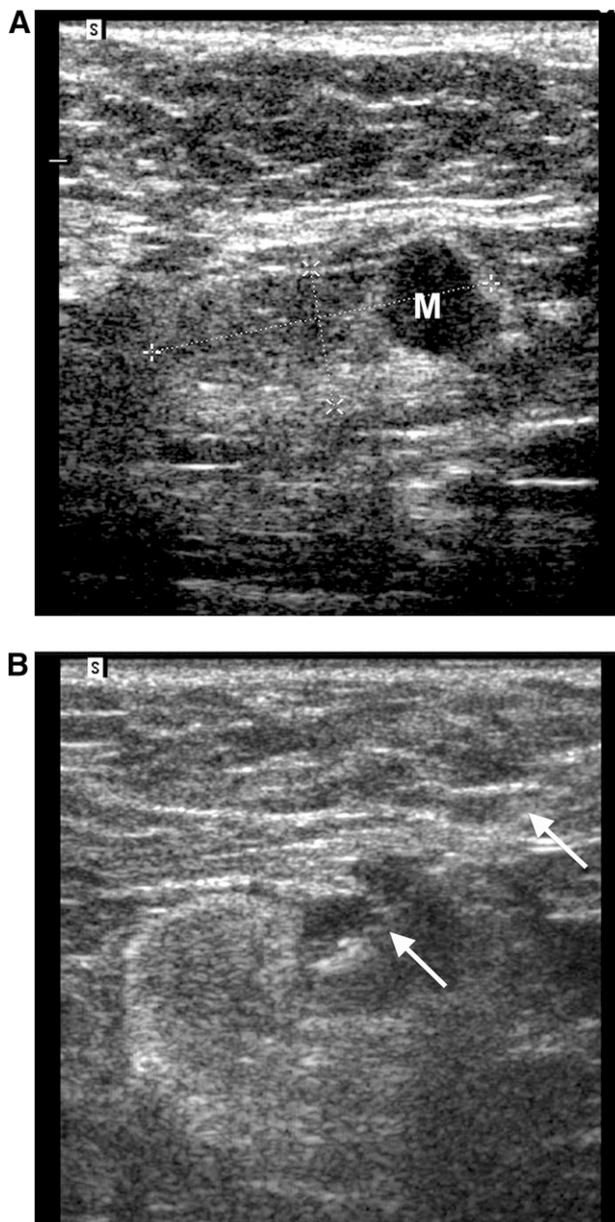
Axillary lymph node metastasis. Ultrasound-guided fine-needle aspiration (FNA). (A): Sonogram shows the markedly hypoechoic malignant deposit deforming the lower pole of an otherwise normal, fat-replaced node (calipers). (B): Sonogram obtained during ultrasound-guided FNA shows the bright tip of the echogenic fine needle (arrows) in the center of the metastatic deposit.
